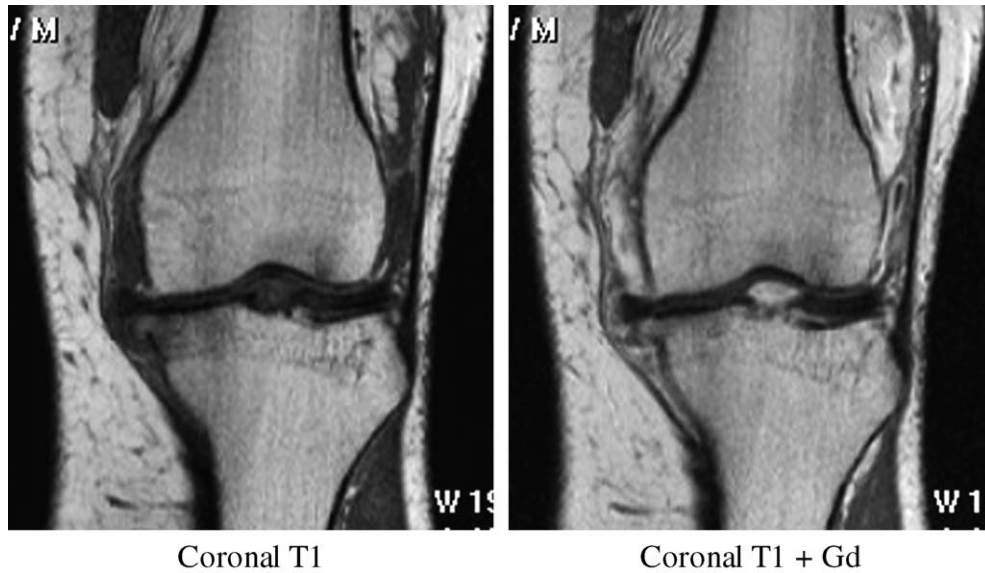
T1-weighted coronal images of an osteoarthritic knee before and after gadolinium demonstrating enhancing synovium (image courtesy of Dr A. Grainger, Leeds UK).
